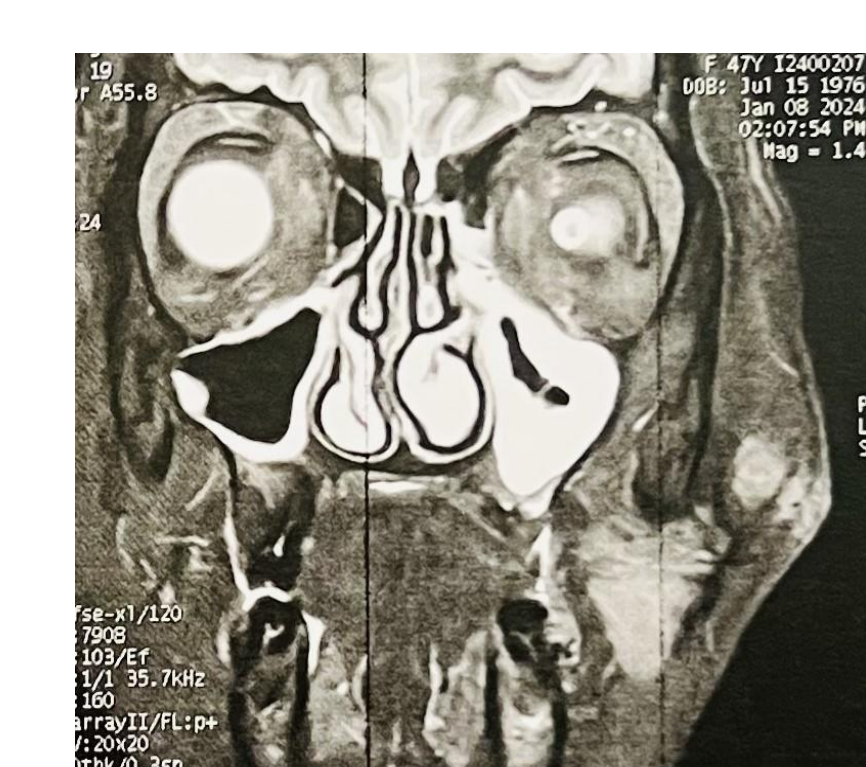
T2 weighted MRI revealing isosignal left subcutaneous mass
